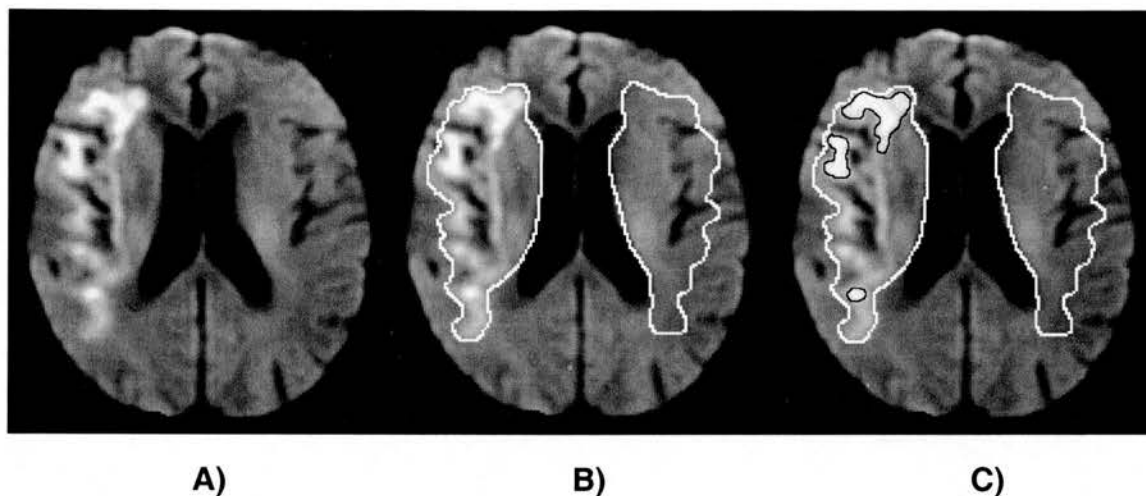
A) DWI of a patient with a right hemisphere ischaemic lesion at 26 days after stroke onset, B) with lesion and homologous contralateral region outlined in white, C) with ‘still hyperintense’ regions outlined in black.
